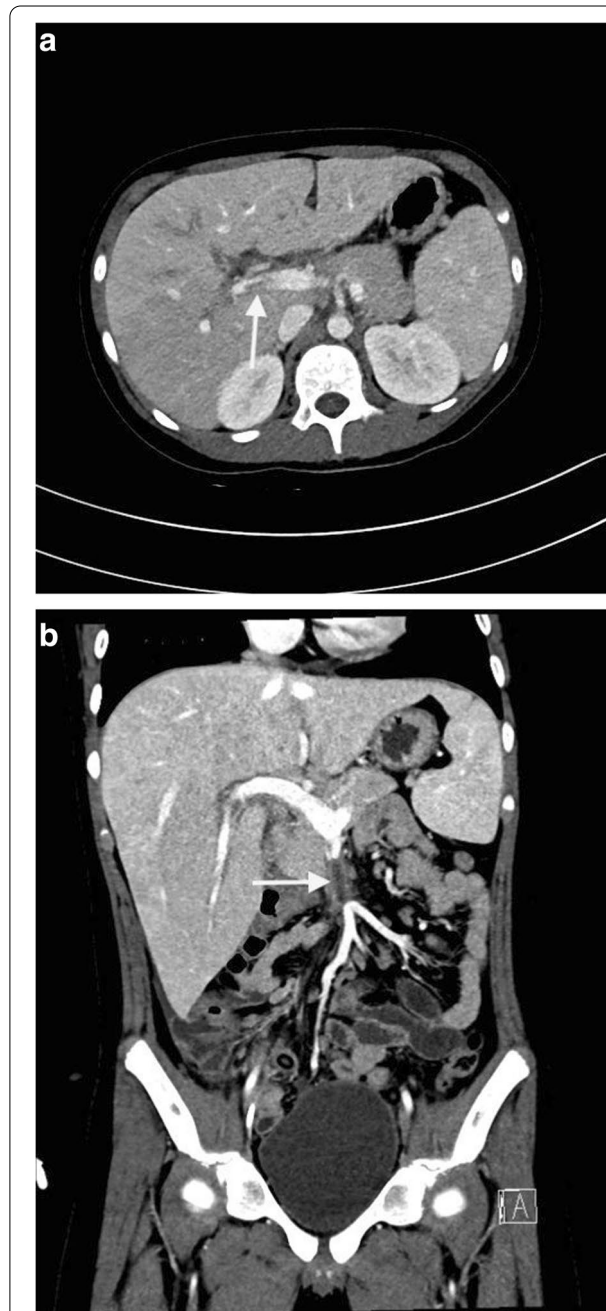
Computed tomography scan on post-operative day 7. a Axial view CT scan showing interval progression of portomesenteric thrombosis involving main portal vein (arrow). b Coronal view CT scan showing interval progression of portomesenteric thrombosis involving superior mesenteric vein (arrow)
